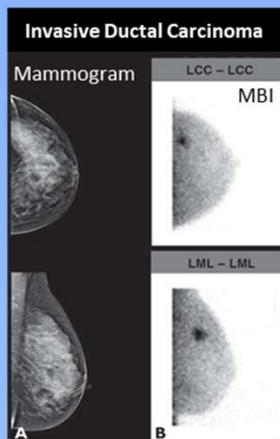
Rechtman et al. (2014) *Breast-specific gamma imaging for the detection of breast cancer in dense versus nondense breasts.* AJR Am J Roentgenol. 2014 Feb;202(2):293-8.
